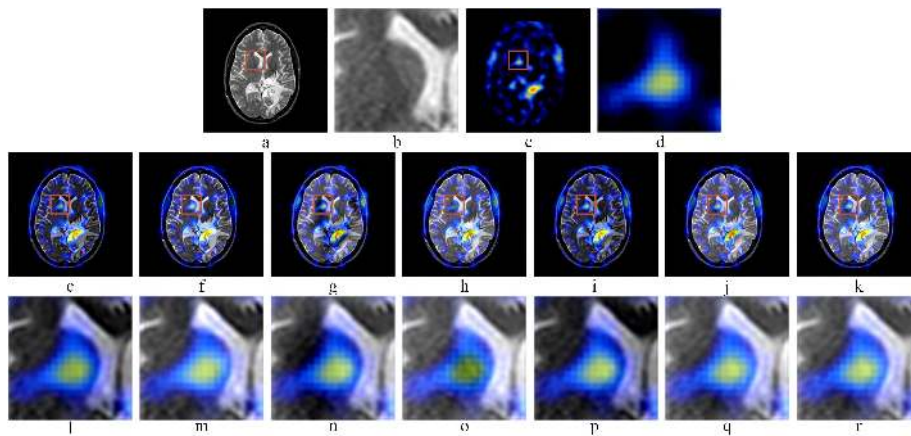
SPECT-MRI image fusion experiments, (a) and (c) are MRI and SPECT source images respectively. (b) and (d) are the local detailed images of (a) and (c) respectively. (e), (f), (g), (h), (i), (j) and (k) are the fused images of ASR, JCPD, MST, NSST, NSCT, NSCT-PC and proposed methods respectively. (l), (m), (n), (o), (p), (q), and (r), are local detailed information of (e), (f), (g), (h), (i), (j) and (k) respectively.
